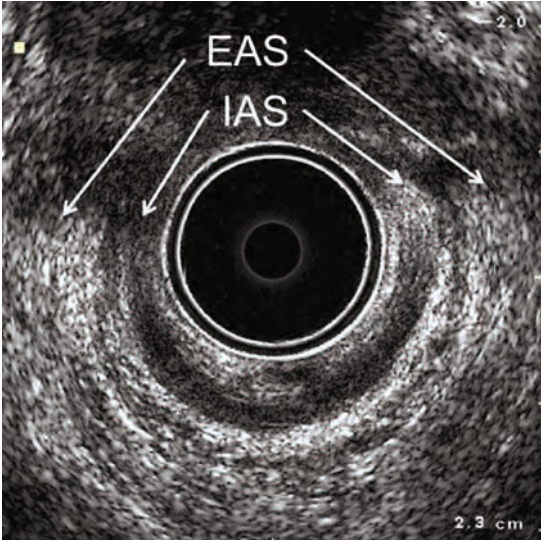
Three-dimensional endoanal ultrasonography. Combined anterior damage of the external (EAS) and internal anal sphincters (IAS) from the 10 o'clock to the 2 o'clock position
